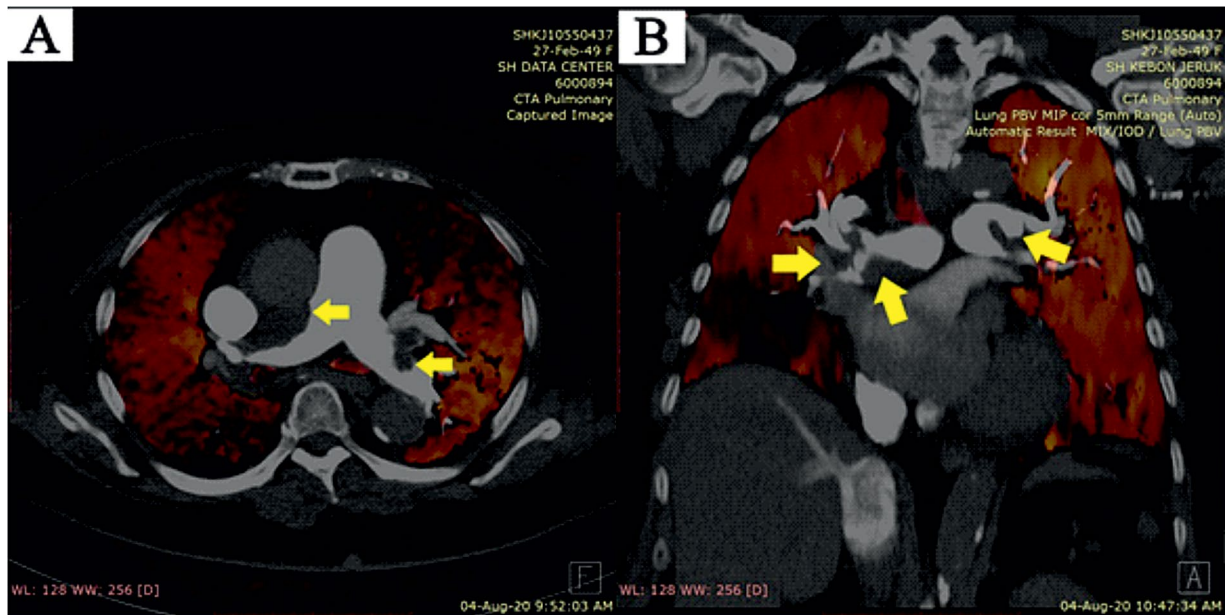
Computed tomography angiography of the pulmonary arteries revealed large thrombus (yellow arrows) at both main branches of pulmonary arteries and the distal branches. A. Axial plane. B. Coronal plane
